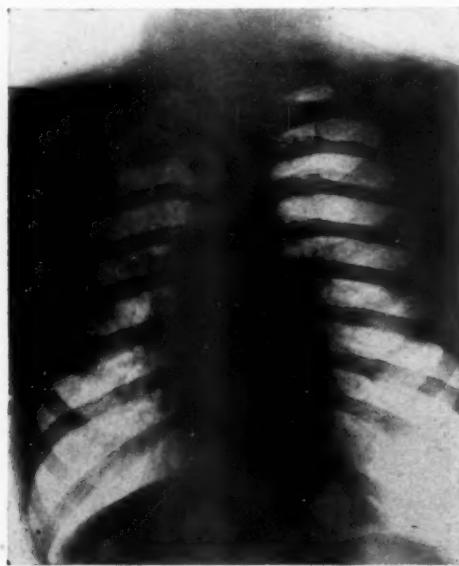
Case 4. Roentgenogram showing spontaneous left pneumothorax.
